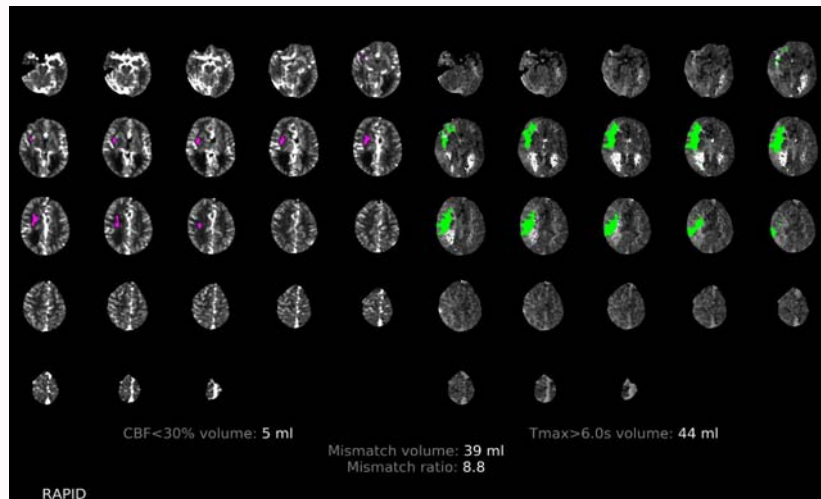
CT Perfusion: Showed a small core of 5 mls with a large penumbra of 44 mls and with a mismatch ratio of 8.8 suggesting a favourable indication towards mechanical clot removal.
